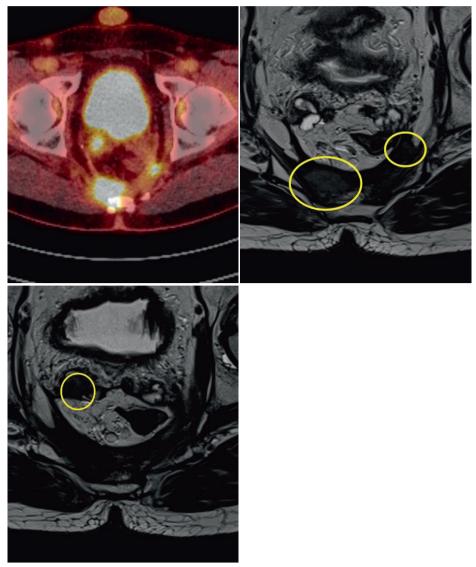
Images from a patient with multifocal recurrence after transanal total mesorectal excision a PET images showing multifocal recurrence. b,c T2-weighted axial MRI images showing left lateral and presacral local recurrence (b) and recurrence in right seminal vesicle (c).
